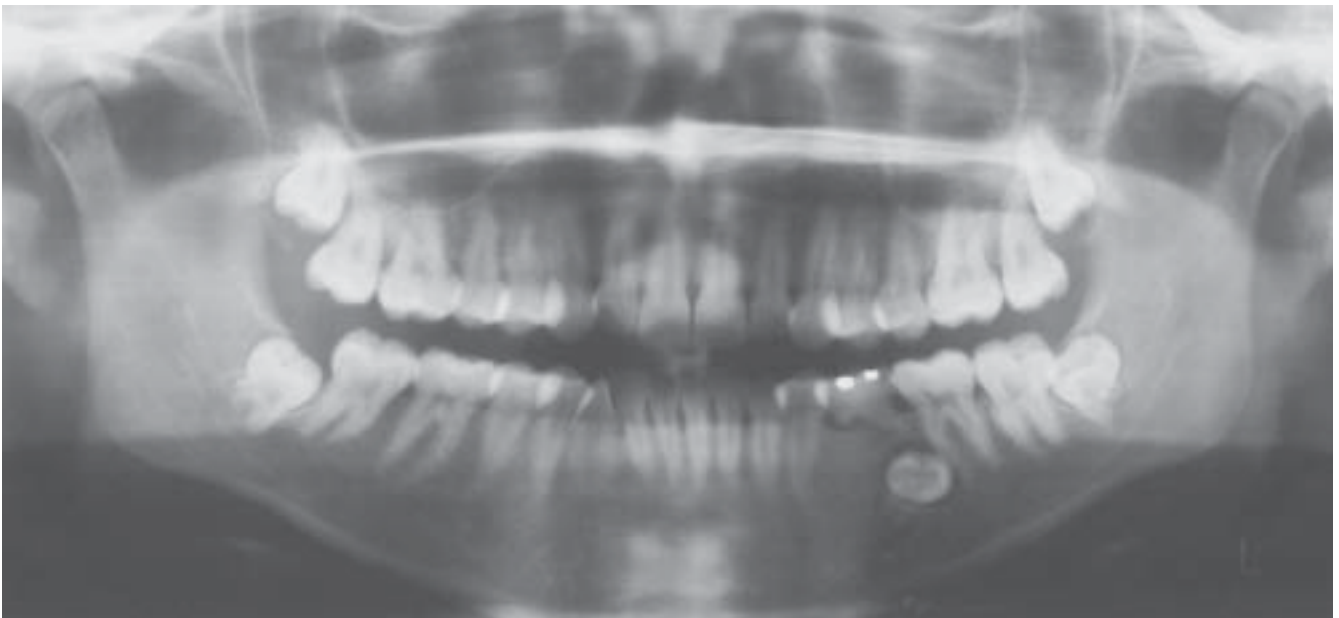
Panoramic radiograph of twin 2
